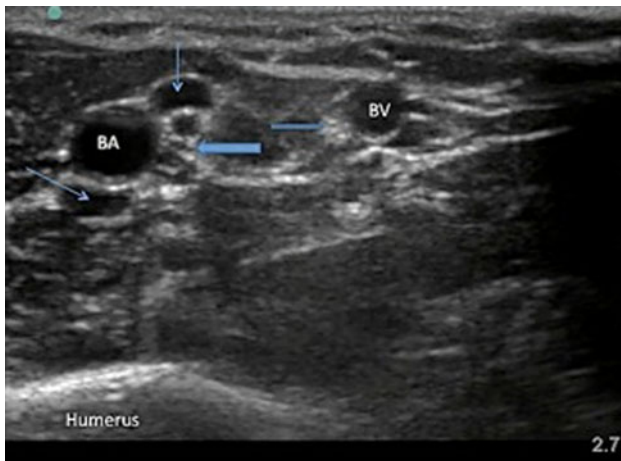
Cross-sectional image of medial aspect of right upper arm, approximately midway between elbow flexure and axilla as viewed from the patient's feet. The depth of field is 2.7 cm. The brachial artery (BA) is accompanied by two partially compressed basilic veins (BV) (venae comitantes *small arrow*) and a nerve plexus (*large arrow*). The basilic vein is usually closely accompanied by the medial cutaneous nerves of the forearm (*medium arrow*). High-resolution ultrasound and accurate needle visualisation allow such collateral structures to be identified and avoided
